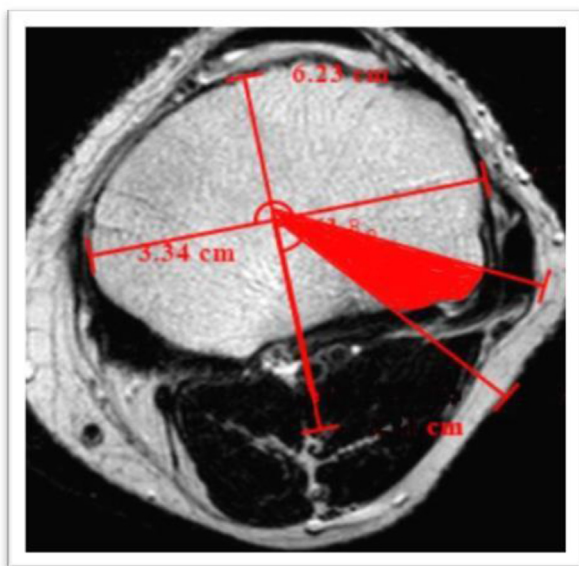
T2 weighted magnetic resonance image at level of tibial cut showing the danger zone, which represents the central 2 standard deviations; lower limit of danger zone 38.9° and upper limit of danger zone 61.3° from the AP axis.
